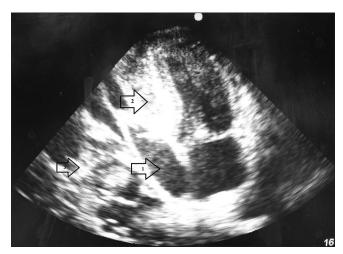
2D echocardiogram apical 4 chamber view showing right atrium (1) and right ventricle (2) compressed by the hepatic cysts (3)
